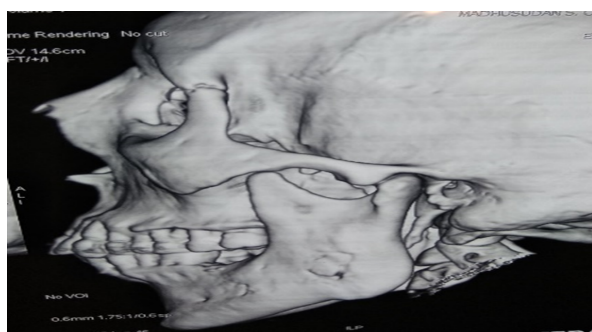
3-dimensional Computed Tomography Image Showing Cortical Perforation At Region Of Left Mandibular Second And Third Molar And At Masseteric Region.
